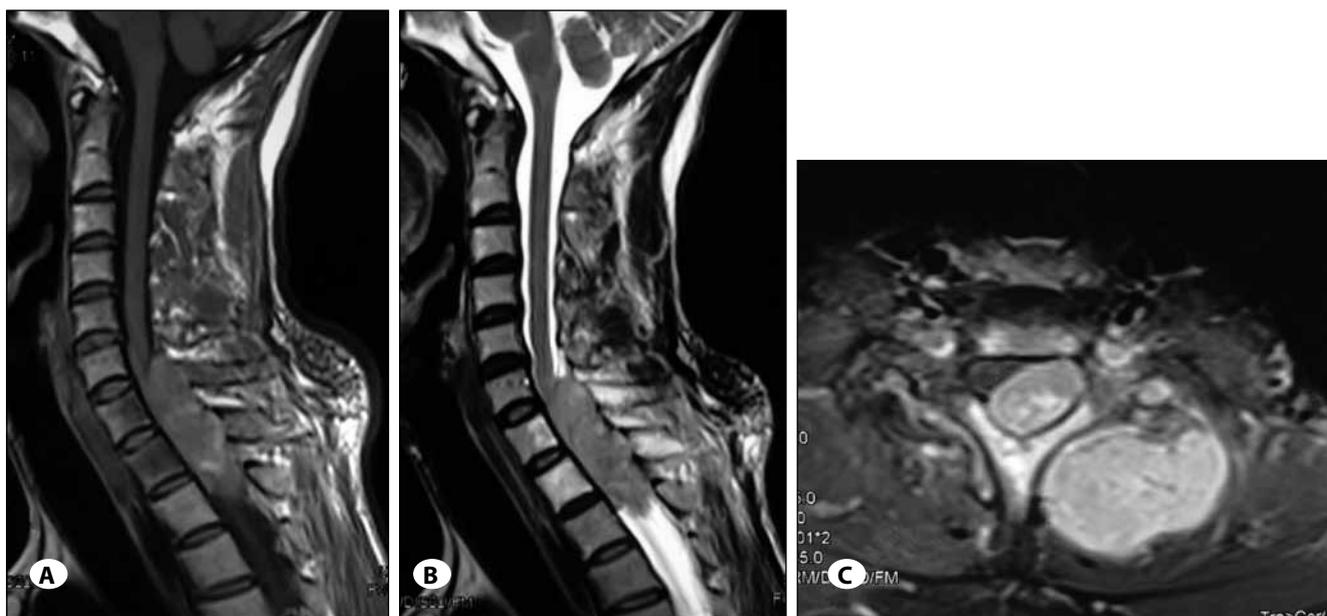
Sagittal magnetic resonance image showed extradural and paraspinal tumor at the C6-T2 level. It was isointense on both A) T1- and B) T2-weighted images. C) Axial T1-weighted magnetic resonance imaging after injection of gadolinium revealed a homogeneously enhancing extradural and paraspinal lesion at the cervicothoracic spine. The preoperative diagnosis was malignant schwannoma, neuroblastoma and neurofibroma.
